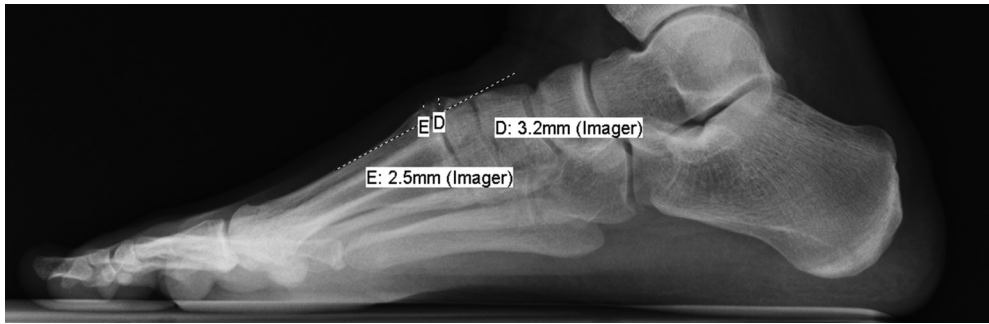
Lateral weightbearing radiograph measuring dorsal protrusion distance of the metatarsal and cuneiform.
